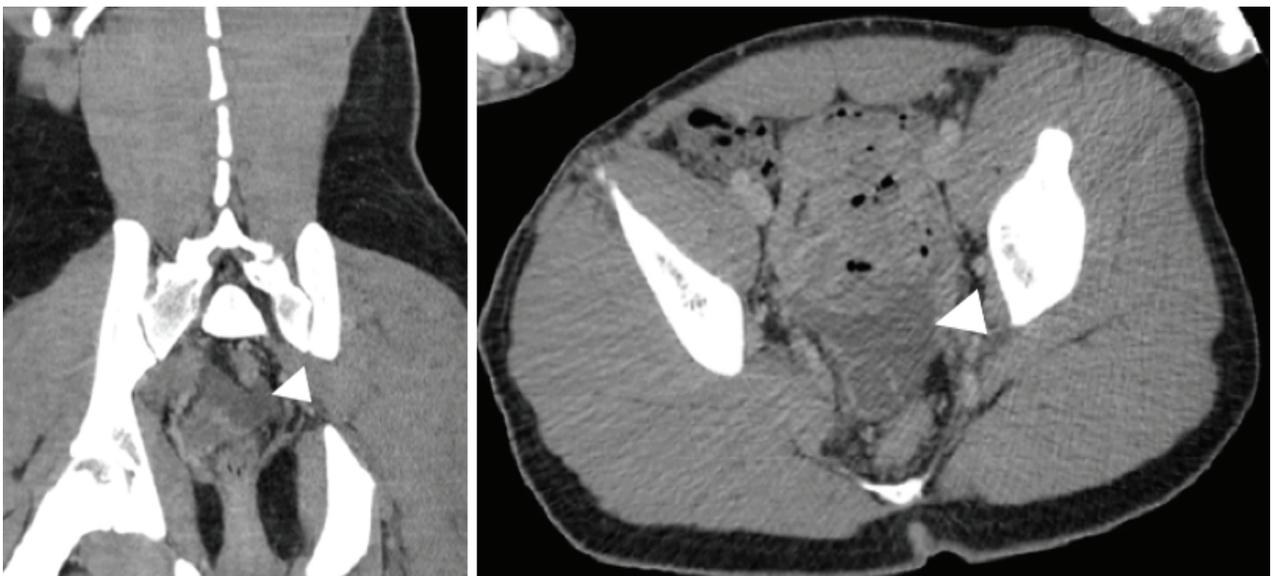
Preoperative computed tomography of abdomen and pelvis showing moderate amount of free fluid in the pelvis (arrowhead)
